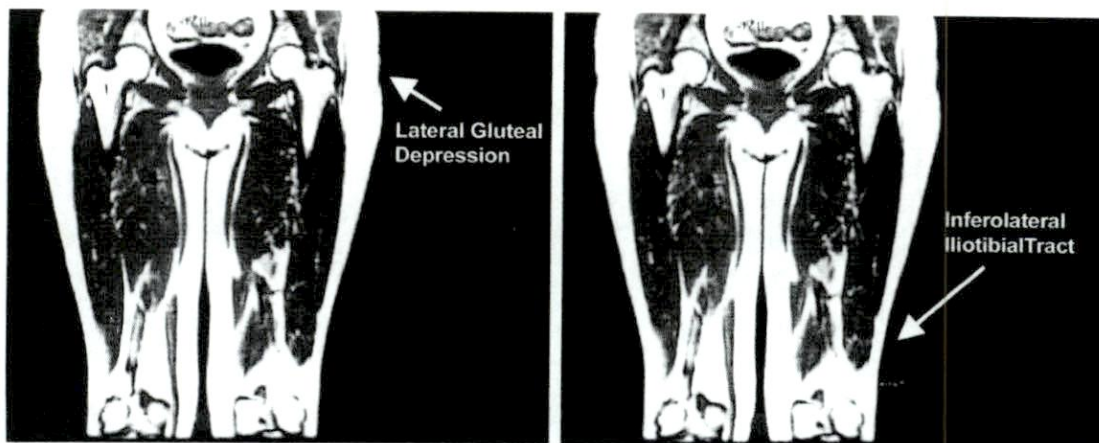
A coronal MRI through the thigh. The subcutaneous fat thins as it moves toward the foot. The zones of adherence occur where the superficial subcutaneous plane is adherent to the underlying muscle fascia. (Left) Lateral gluteal depression adherence zone. (Right) Iliotibial tract adherence zone.
